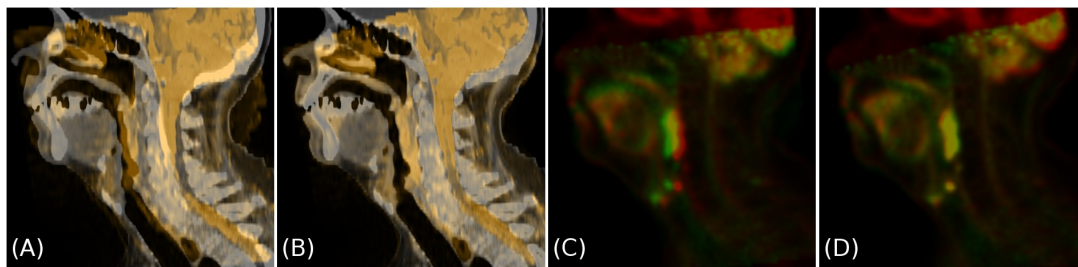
Fusion images after RR and DR for Patient 4. Fusion of the original CT (grey) and the deformed MR (orange) after RR (A) and after DR with LMI+BEP (B). Fusion of the PET of the PET/CT (red) and the deformed PET of the PET/MR (green) after RR (C) and after DR with LMI+BEP (D).
